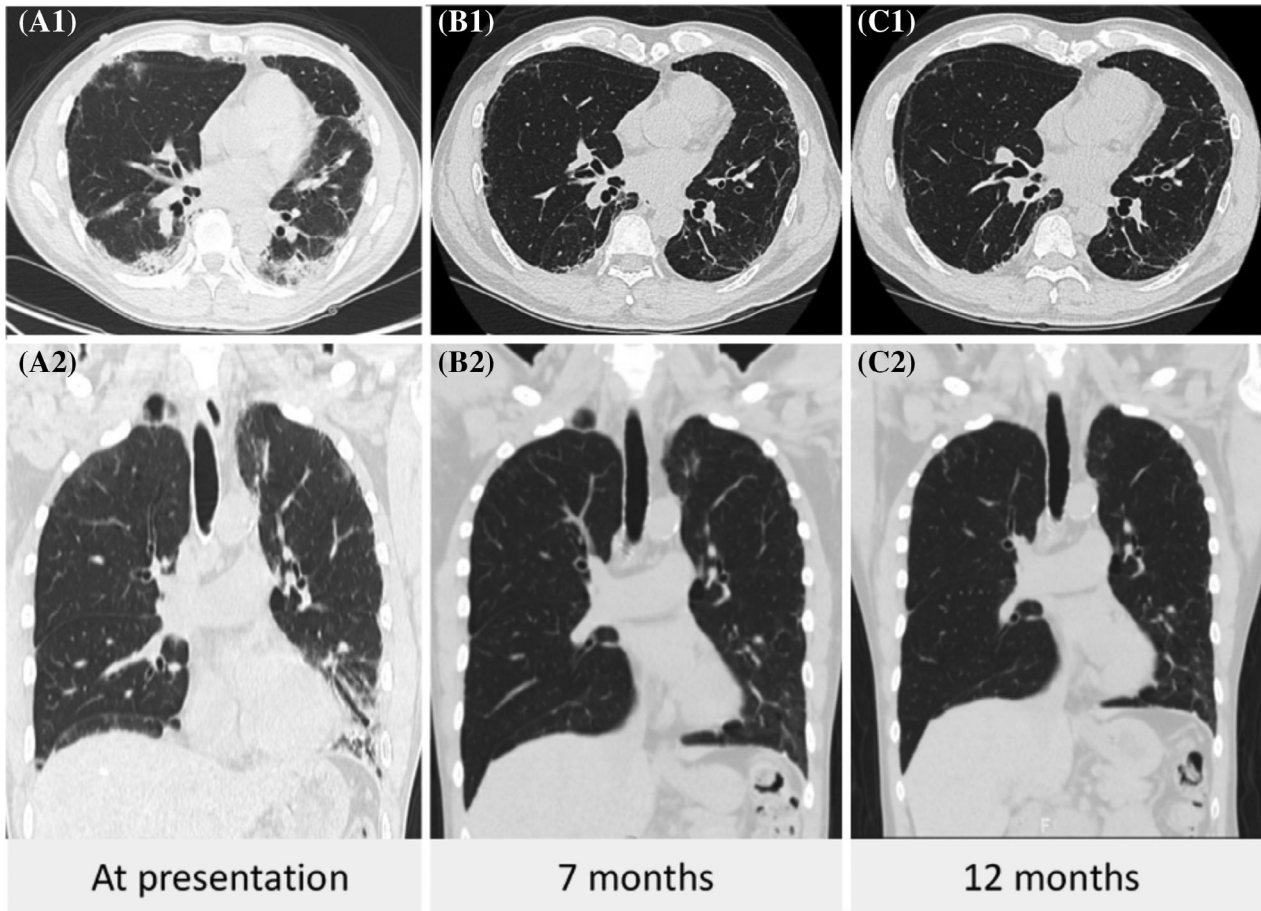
Serial axial (A1, B1, C1) and coronal (A2, B2, C2) images of chest computed tomography at presentation, 7 months and 12 months, respectively
